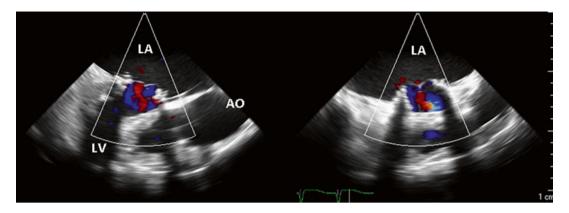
2D TEE color Doppler, x-plane view, status post re-do tissue MV replacement, showed normal mitral inflow and minimal MR
